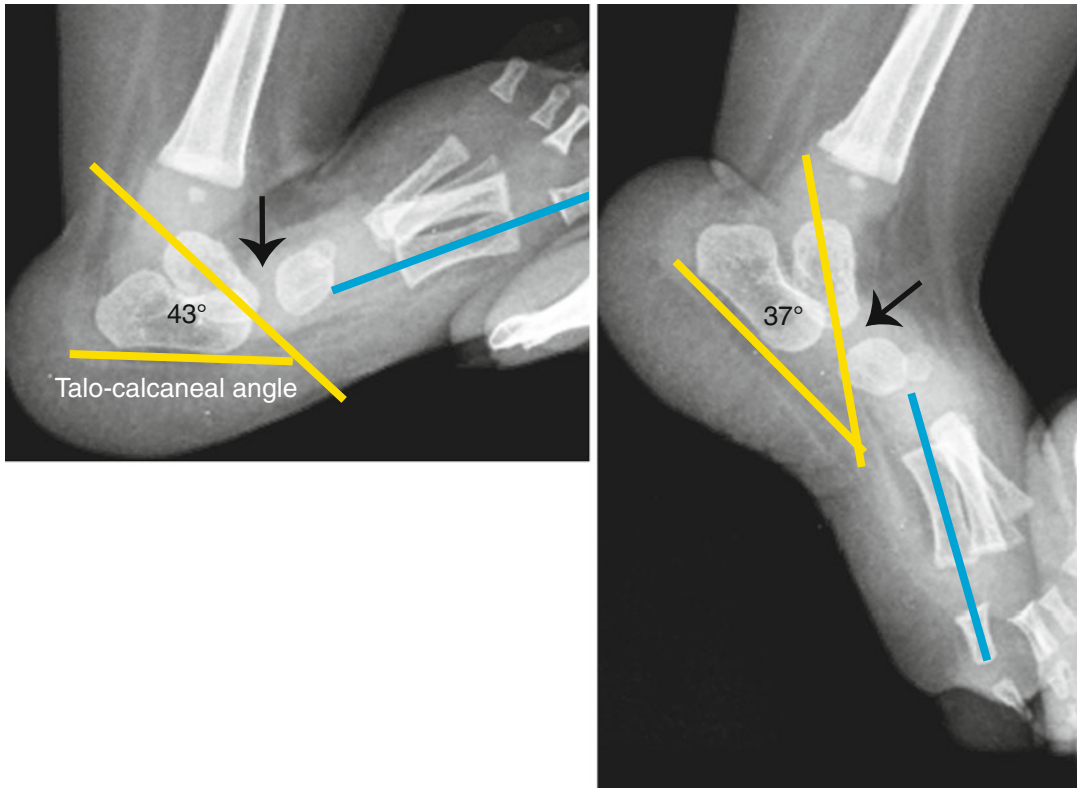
Lateral radiographs of the foot of an infant with an oblique talus. In the dorsiflexion film, the talus appears severely plantarflexed, the midtarsal joint is subluxed (arrow), and the axis of the first metatarsal (blue line) is not aligned with the long axis of the talus. When the foot is plantarflexed, the talocalcaneal angle between the long
